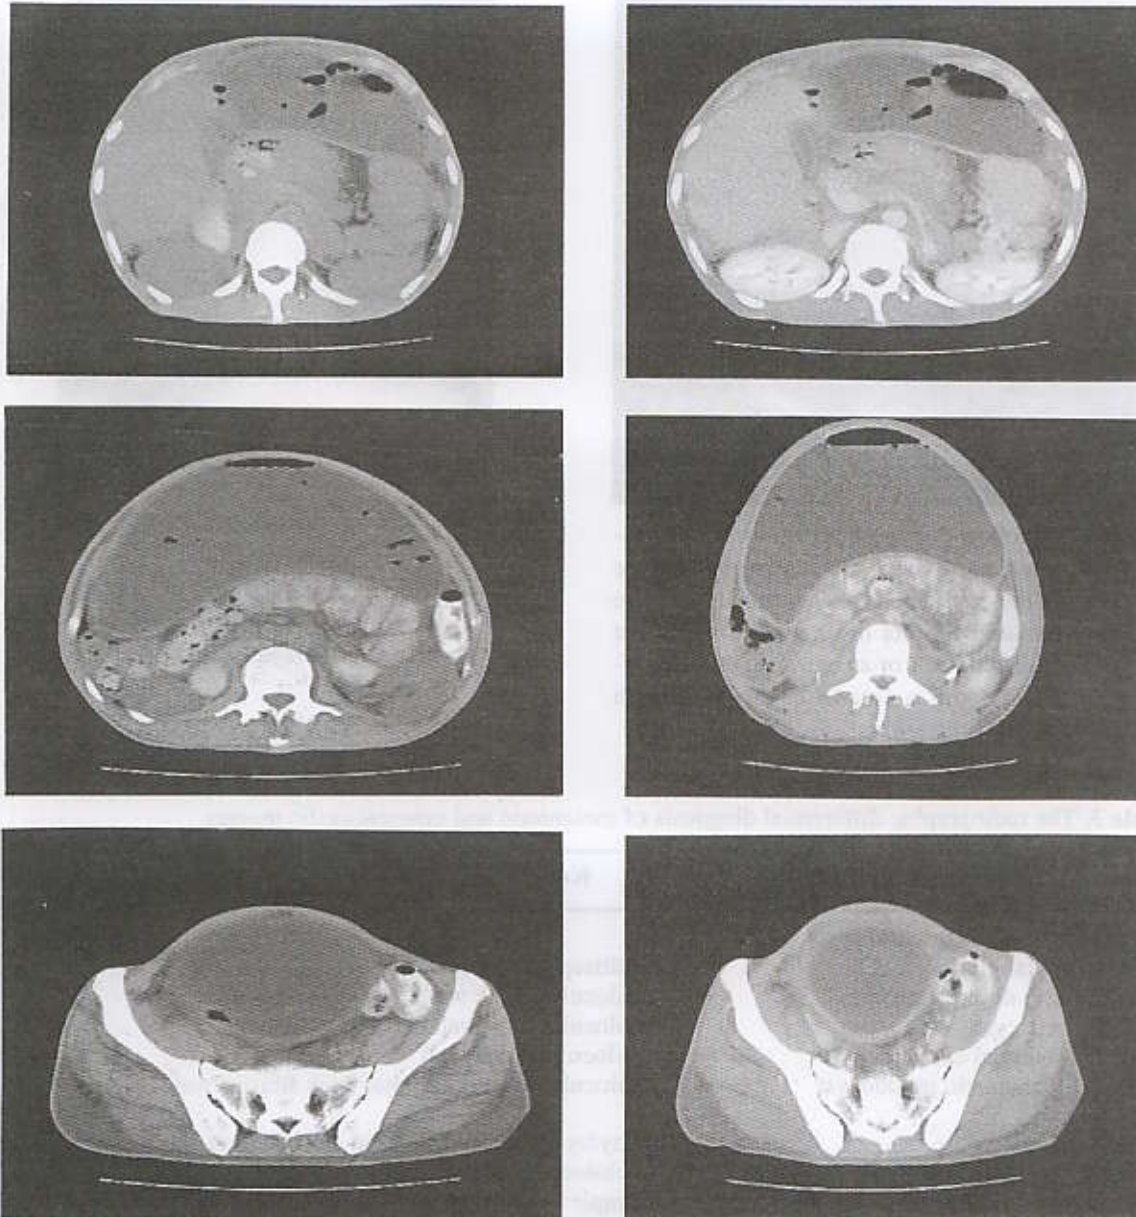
Non enhanced CT scan (a to c) shows a large, well defined, cystic mass with multiple septations in the peritoneal cavity. It displaces the stomach and bowel loops posteriorly. A very small amount of free fluid is seen coating the liver surface. No calcification or intraabdominal lymphadenopathy is detected. Noted air within the lesion due to previous laparoscopy. Enhanced CT scan (e to f) shows a thick enhancing wall of the lesion. Other structures are unremarkable.
